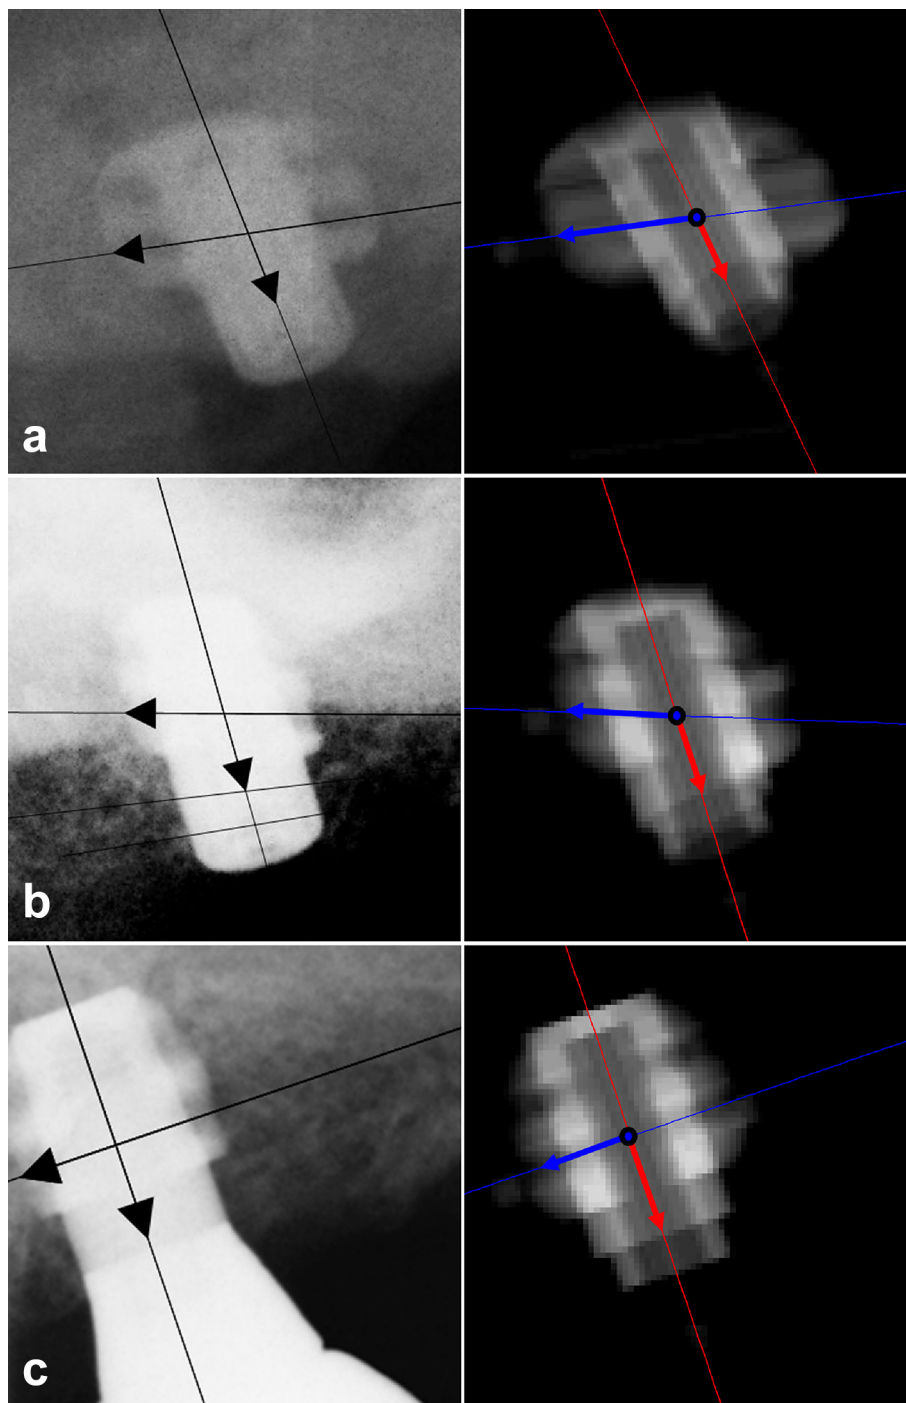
Radiographs of Patient #6 (excluded from analysis of the marginal bone level) and related virtual ghosts with estimated components obtained by Measurer 1 in Session 1: (a) $\vec{OA}_Y + 0.8882 \vec{OA}_Z - 1.8852 \vec{OB}_Y - 3.4329 \vec{OB}_Z - 0.4391$ at baseline; (b) $\vec{OA}_Y + 0.6824 \vec{OA}_Z - 2.1852 \vec{OB}_Y - 2.4088 \vec{OB}_Z + 0.0855$ at 4 months; (c) $\vec{OA}_Y + 0.7540 \vec{OA}_Z - 2.2363 \vec{OB}_Y - 2.0650 \vec{OB}_Z + 0.7180$ at 12 months;
